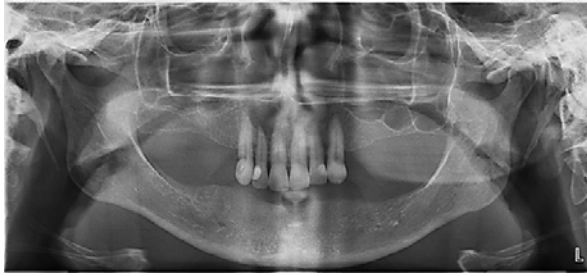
Optimal Panoramic Radiograph.
